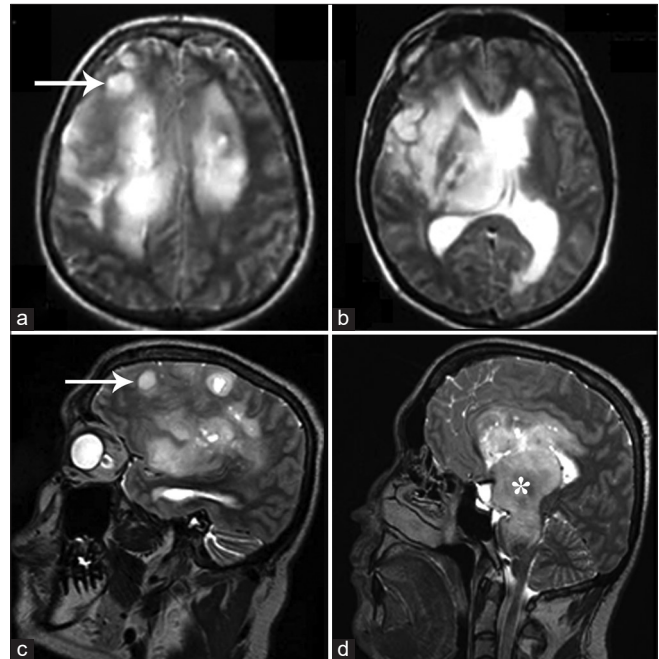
T2-weighted axial (a and b) and sagittal (c and d) images of magnetic resonance imaging brain showing multifocal T2 hyperintense lesions demonstrating mass effect, involving the thalamus, and extending into the brainstem (white asterisk in D). Some of the lesions were cortical and subcortical in location (white arrows in a and c) and cystic changes were also present.
